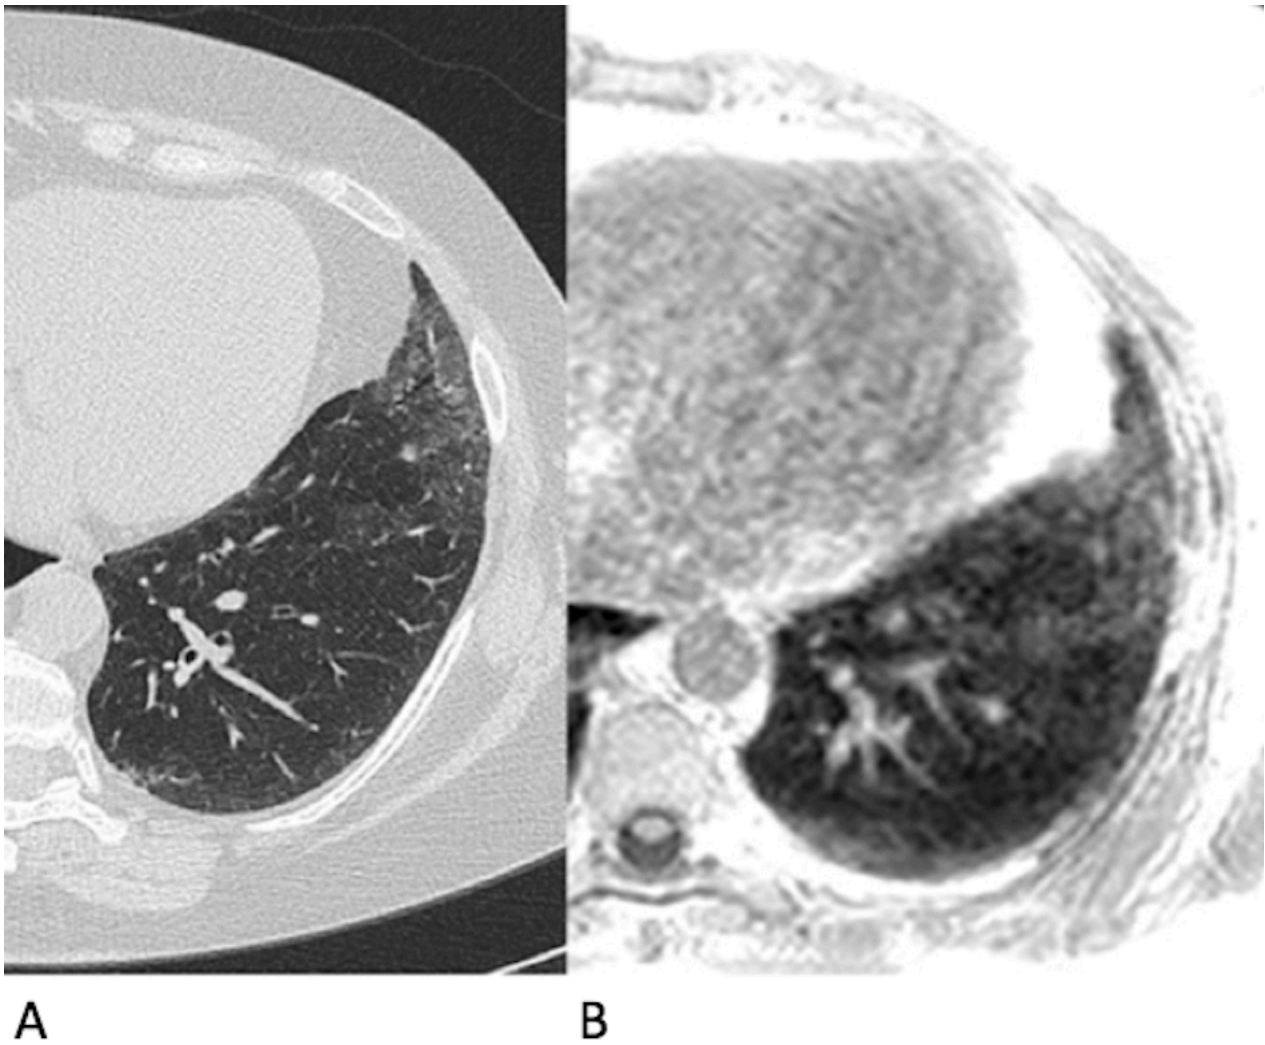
SSc-ILD, left lung: ground glass opacities on CT and UTE.
